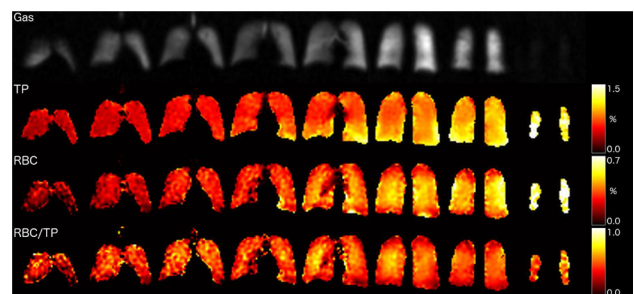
Ventilation and dissolved-phase MRI in healthy volunteer HV9.
